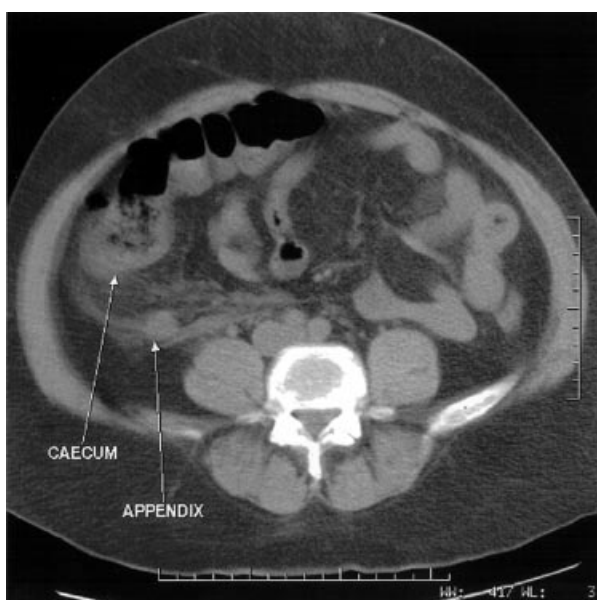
CT examination of appendicitis.
